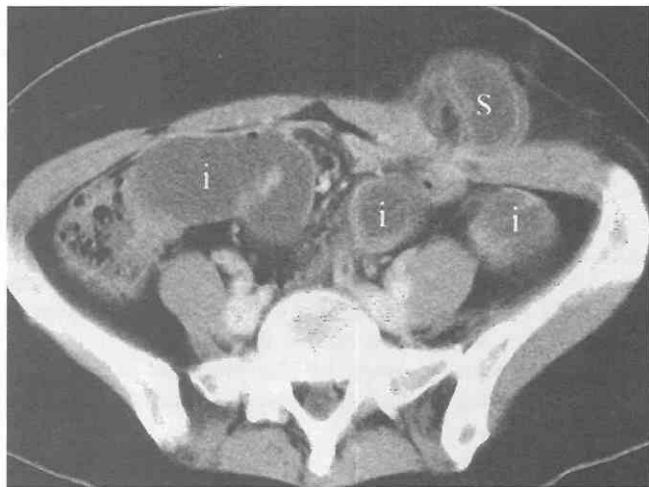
Incarcerated spigelian hernia. CT scan shows bowel thickening, with the “target sign” in the small-bowel loop (S) herniated into the hernia sac, along with diffuse small-bowel dilatation (i) caused by obstruction.
